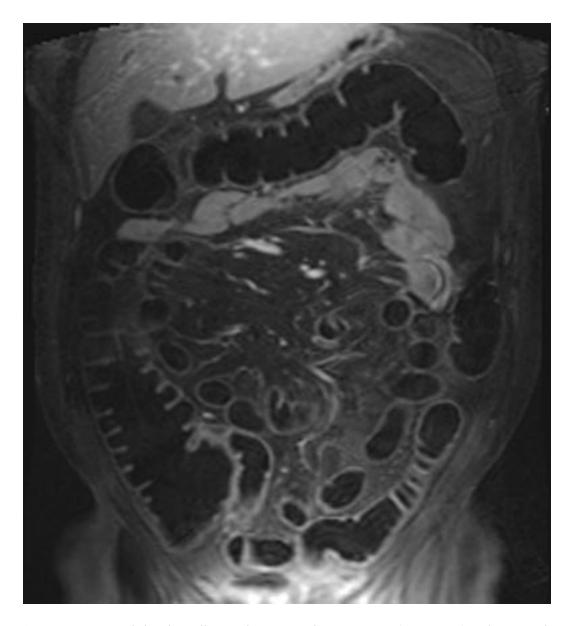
T1-weighted gradient echo magnetic resonance (GRE MR) colonography image
